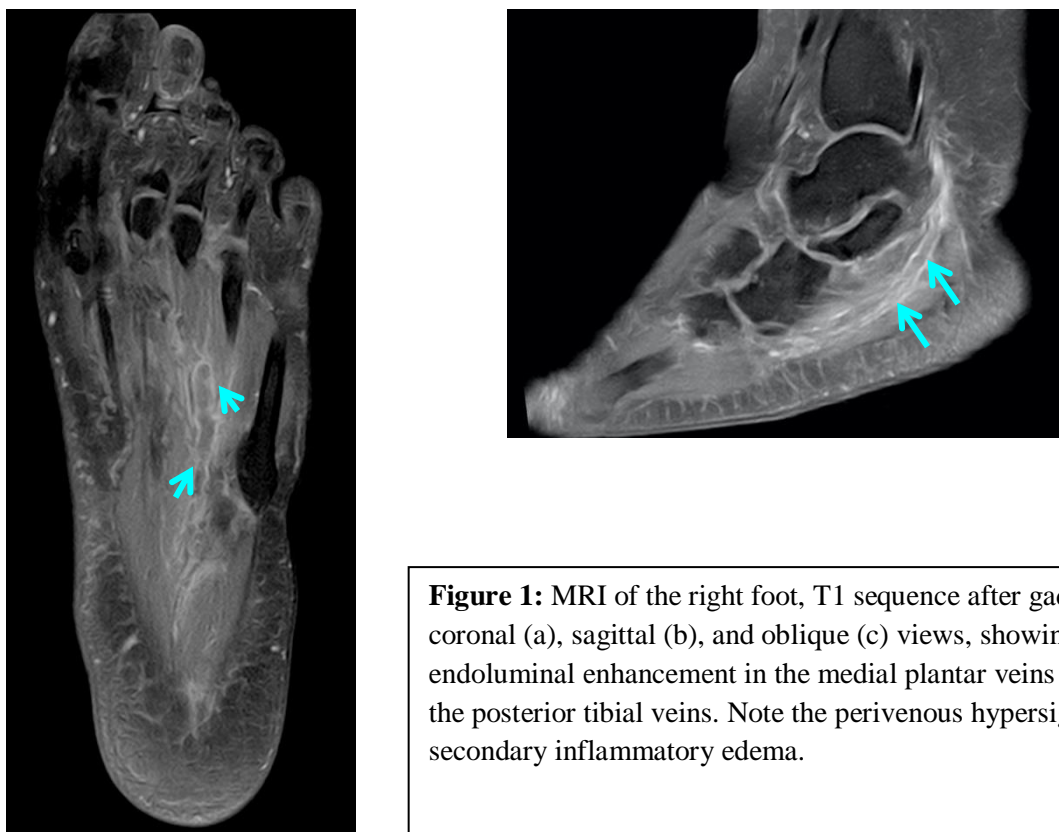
MRI of the right foot, T1 sequence after gadolinium injection, in coronal (a), sagittal (b), and oblique (c) views, showing an absence of endoluminal enhancement in the medial plantar veins (→), extending into the posterior tibial veins. Note the perivenous hypersignal indicative of secondary inflammatory edema.
